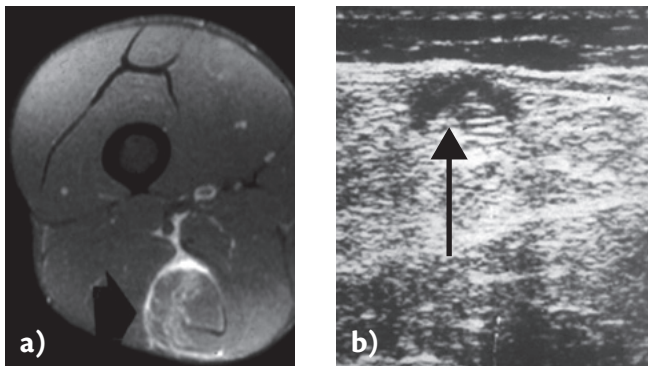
Imaging (MRI a) showing intramuscular injury with intermuscular bleeding (courtesy of Magnus Tengvar, Sophia Hospital, Stockholm) and b) ultrasound of injured hamstring muscle. Arrow indicates location of tear.
